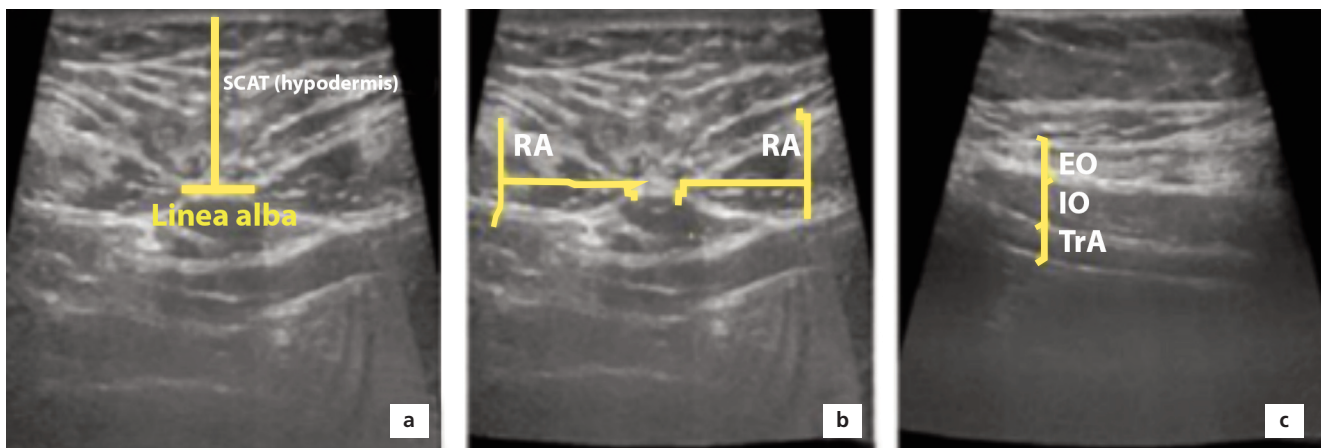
Ultrasound imaging showing measurements. (a) Umbilical SCAT measurement; (b) RA muscle thickness; (c) EO, IO and TrA muscle thickness. EO: external oblique; IO: internal oblique; RA: rectus abdominis; SCAT: subcutaneous adipose tissue; TrA: transversus abdominis.
